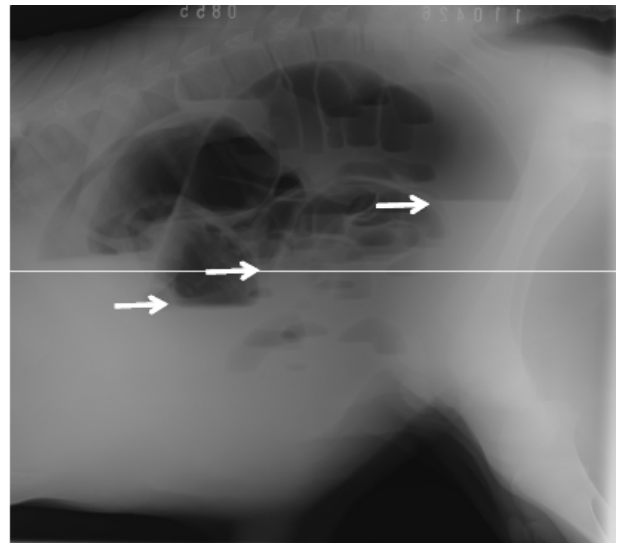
Plain radiograph showing the presence of multiple air fluid levels in the abdominal cavity (arrows) and gas in the rectum
